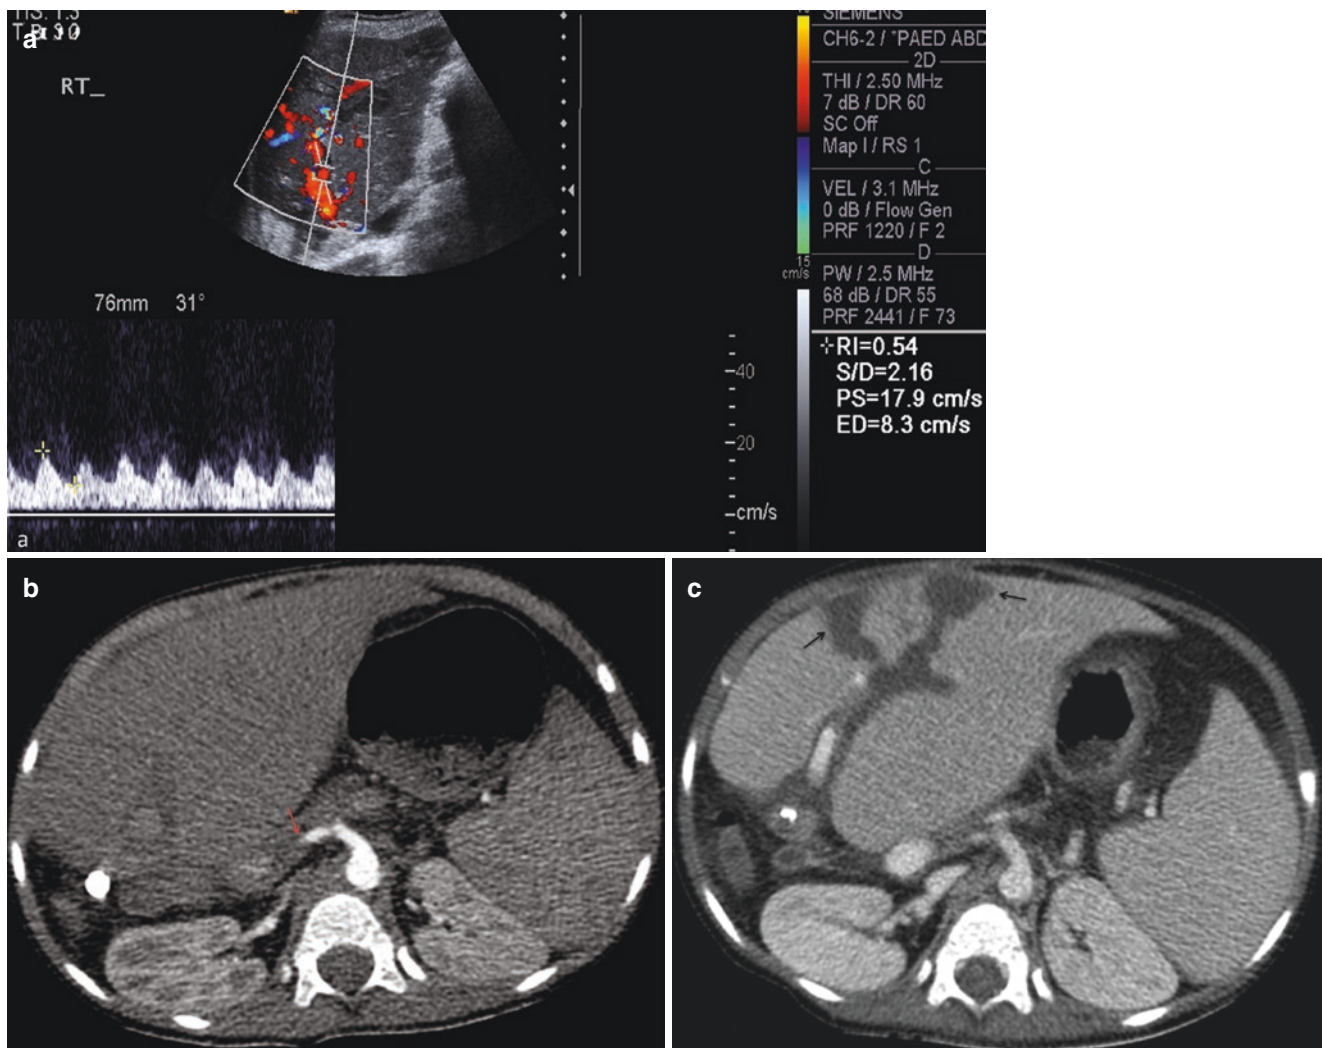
Doppler US scan of a left lateral segment transplant liver. There is a pulsus tardus parvus in a collateral of the hepatic artery with a prolonged acceleration time and reduced peak systolic velocity (17.9 cm/s). (b) CT angiogram confirms the finding of a thrombosed
